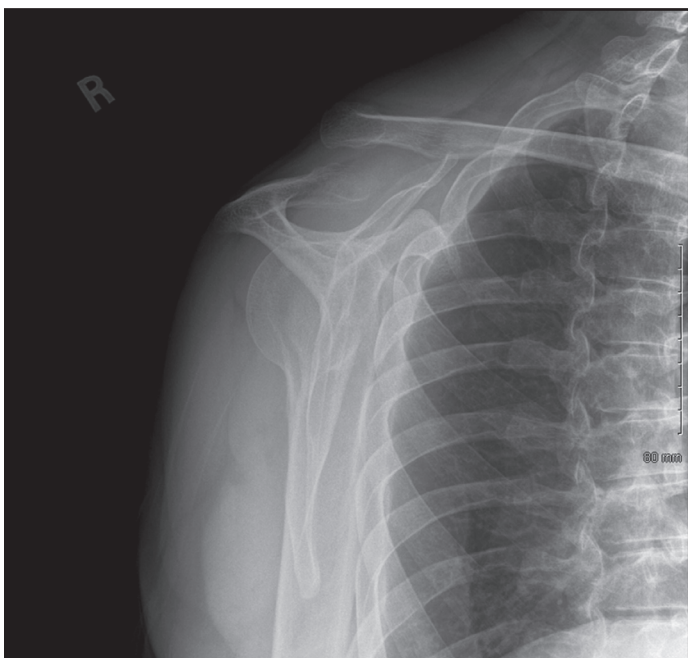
This modified lateral view radiograph was completed because of the subject's intolerance (due to pain) of alternate positioning requested by the radiological technician.
